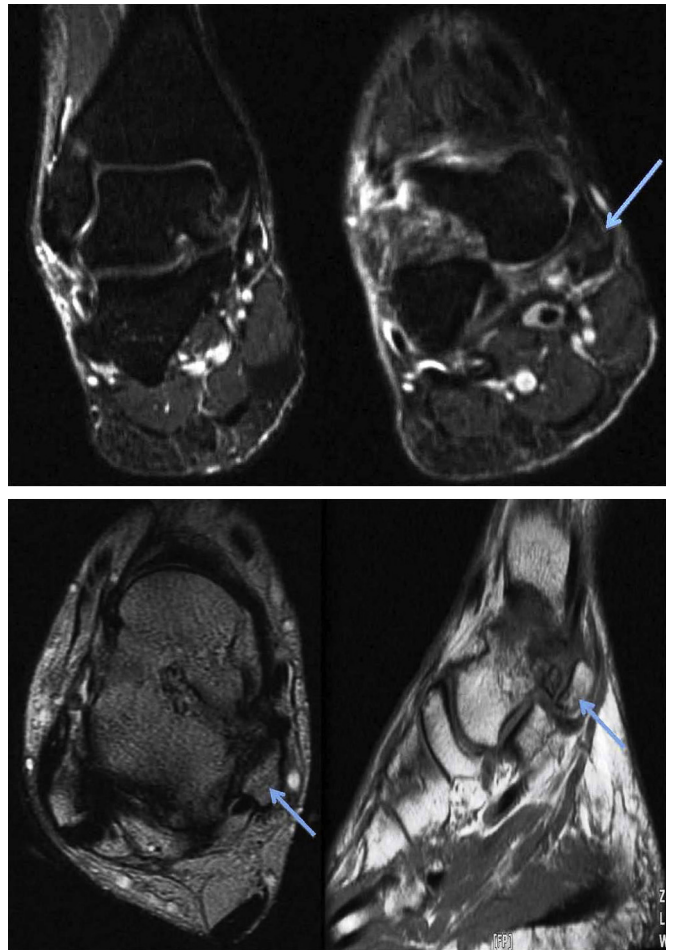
Magnetic resonance images showing a nonunited fracture of the posteromedial tubercle of the talus.
